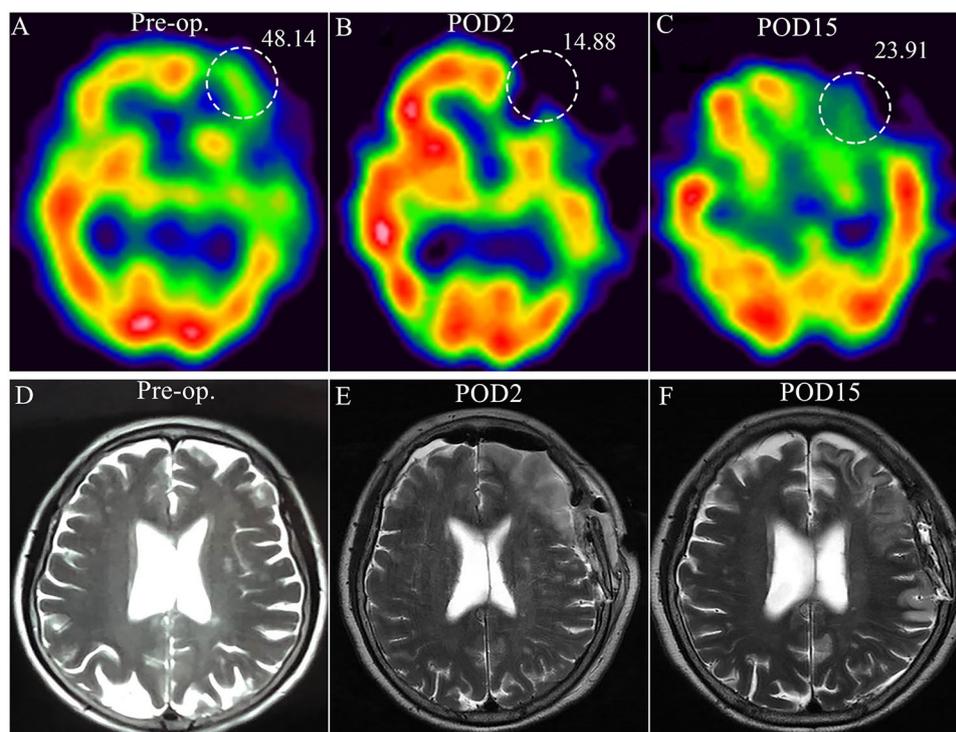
Temporal profile of ^{123}I -IMP-SPECT images and MRI.
